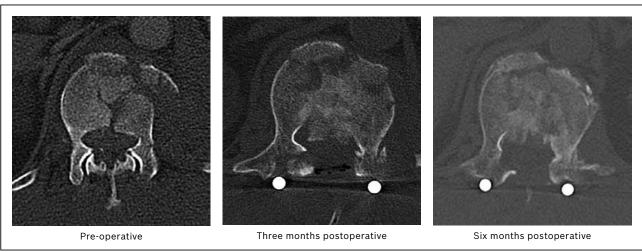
Serial CT images show resorption of the retropulsed fragments of the same fracture.
